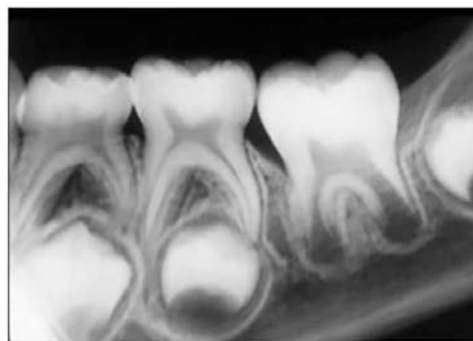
Periapical radiograph of posterior primary and developing permanent teeth.
